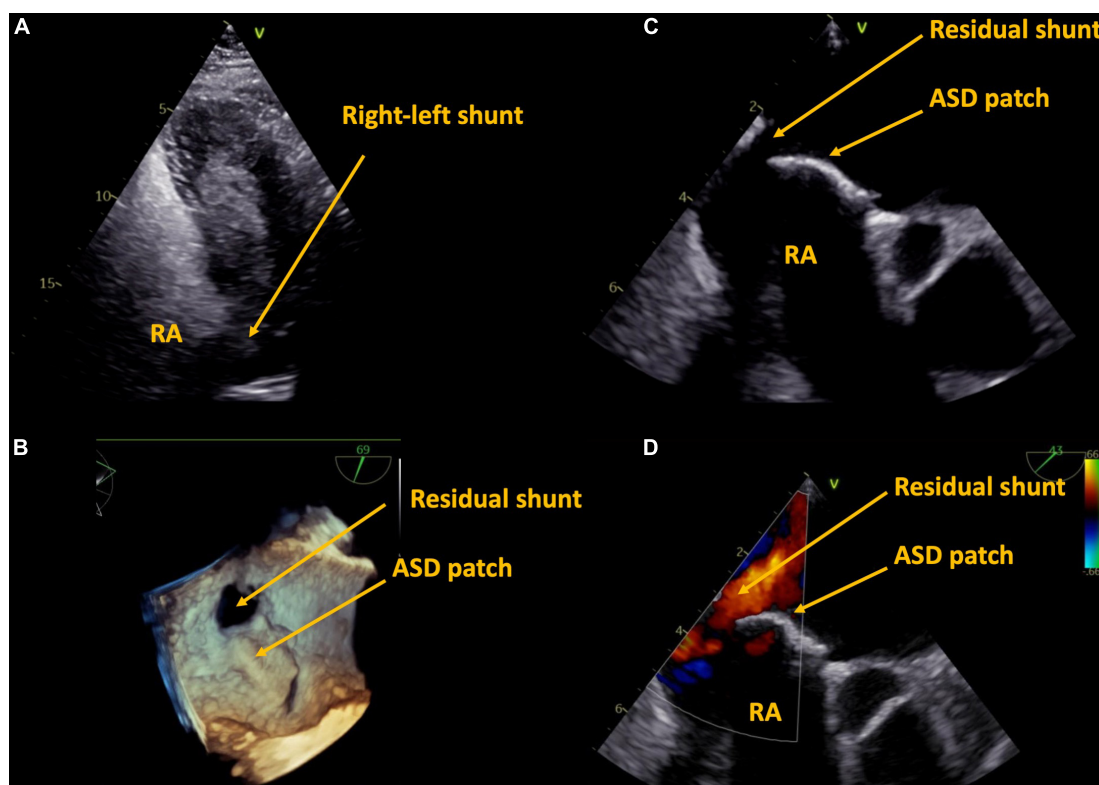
Case 1, 59 year-old patient with a history of surgical ASD closure with partial detachment of the patch. Residual shunt shown by right-heart contrast agent (A), and by transesophageal echocardiography in 3D (B), 2D (C), and 2D color (D). ASD, atrial septum defect, RA, right atrium.
